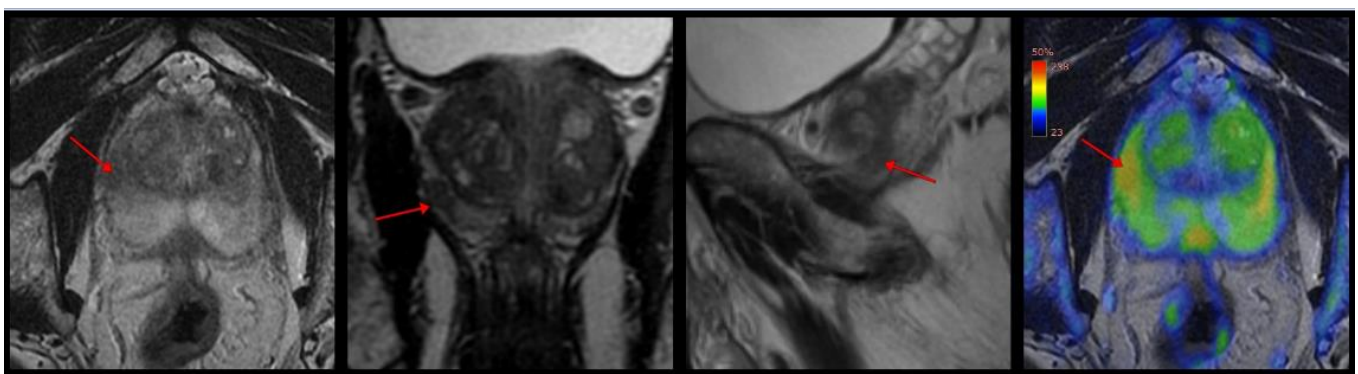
MRI of the anterior peripheral zone PCa
